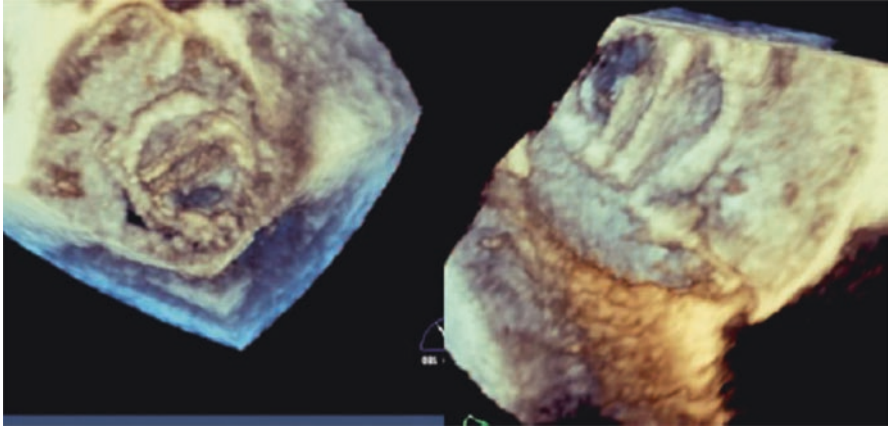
Three-dimensional echocardiography and percutaneous closure of paravalvular leaks. The enface view of the mitral valve obtained by real-time 3D echocardiography is especially important in the percutaneous closure of prosthetic paravalvular mitral regurgitation, as it provides the interventionist an anatomical orientation of the paravalvular regurgitation and the valve leaflets and surrounding structure. In this example, the defect is identified in the posterior aspect of the mitral prosthesis (*left panel*). In combination with other 2D and color Doppler views, a guidewire is successfully passed through the defect with subsequent successful deployment of the closure device (*right panel*)
